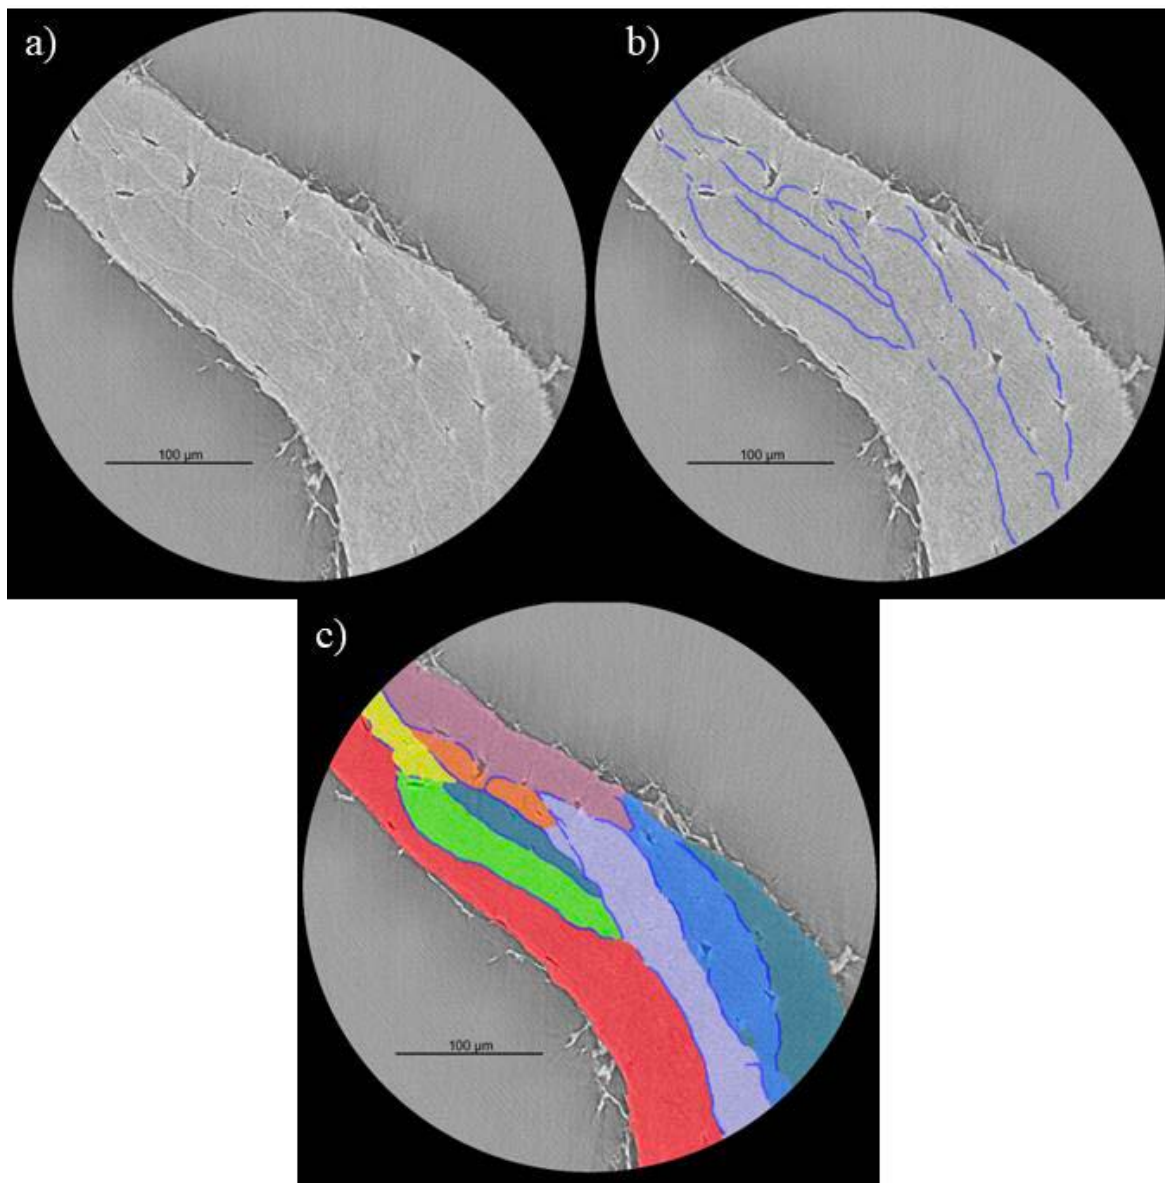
2-D μ CT images acquired at 50kv and 0.25 μ m. a) raw 2-D reconstruction of μ CT data, b) U-Net segmented cement line interfaces (blue), c) watershed transform identified BSU (various colours).
